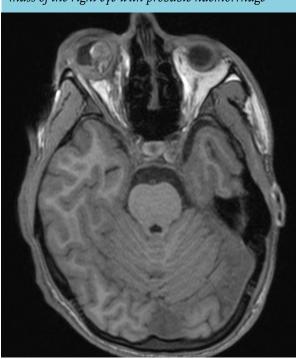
Head MRI (T1-sequence), an intraocular mass of the right eye with probable haemorrhage
